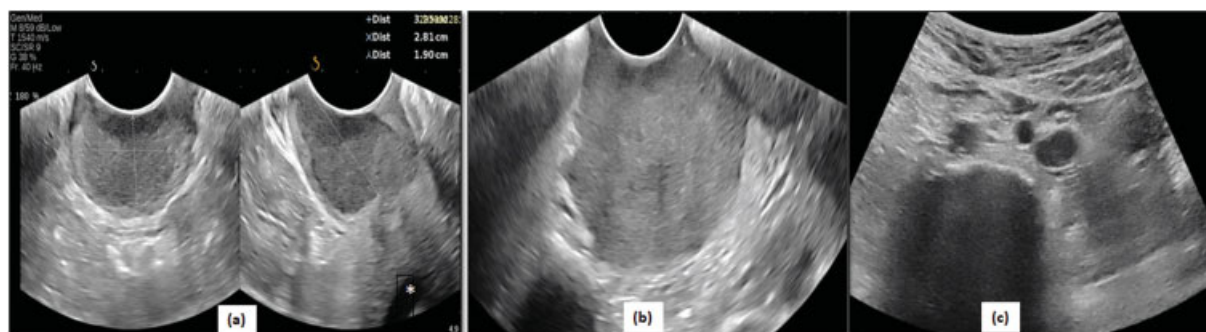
Transvaginal (TVS) ultrasound in carcinoma cervix—(a) Transverse and longitudinal gray scale TVS images showing a hypoechoic solid cervical mass well demarcated from the surrounding cervical stroma. (b) Gray scale TVS image shows large cervical mass with bilateral parametrial infiltration. (c) Transabdominal ultrasound shows enlarged hypoechoic left para-aortic nodes, thus upgrading the stage-to-stage IIIC for the patient.
